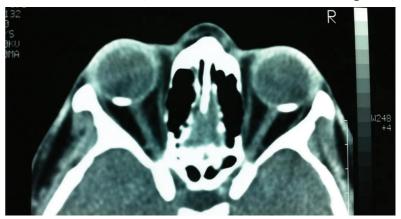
CT demonstrates a dense plaque-like opacity at the level of the choroid at the posterior poles.
